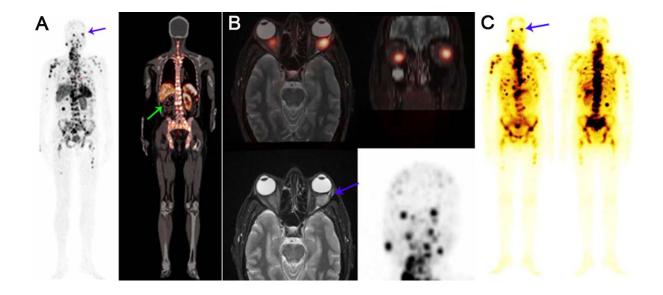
⁶⁸Ga-DOTATATE PET/CT (A) showing increased tracer uptake in widespread metastatic skeletal lesions, cervical, mediastinal, abdomino-pelvic lymph nodes and bilateral orbital soft tissue lesions. MRI of head (B) showed oval to rounded T2-hyperintense and T1-hypointense lesions with moderate homogenous enhancement involving left lateral rectus, left inferior oblique, right lateral rectus and right inferior oblique in intra-conal locations with compression of left optic nerve alongwith abnormal tracer uptake on fused PET/MRI. Post-PRRT scan (C) at 24 hrs after PRRT demonstrate adequate tracer uptake in multiple metastatic lesions.
